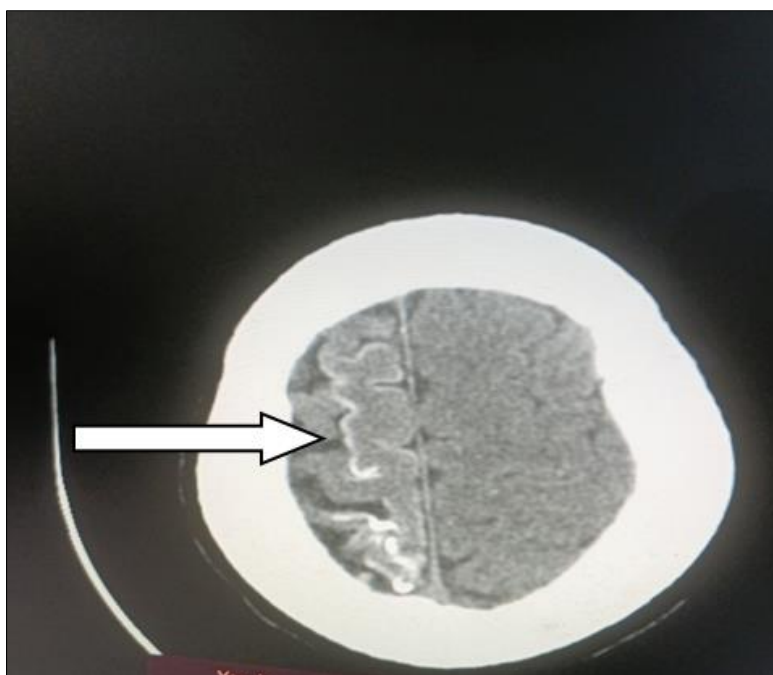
Non contrast enhanced cranial computed tomogram showing reduction in volume of right cerebral hemisphere (arrow) with areas of tram track gyral calcifications (HU = 126)
